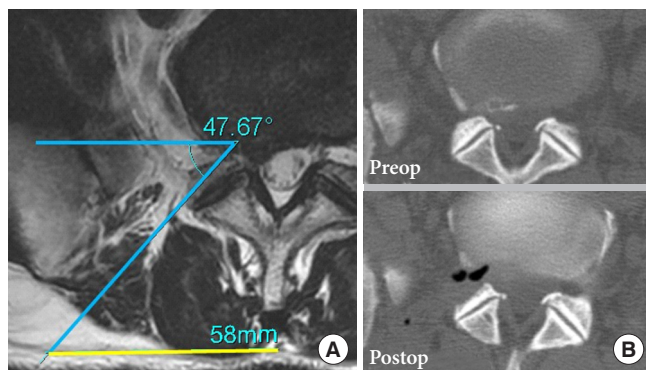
(A) Preoperative measurement of the entry point. The entry angle (blue angle) and the distance of the skin entry point from the midline (yellow line) were calculated on axial magnetic resonance image at the L5/S1 disc level. (B) The exact area removed from the superior articular process was confirmed by comparison between the preoperative (preop) and postoperative (postop) computed tomography images.
